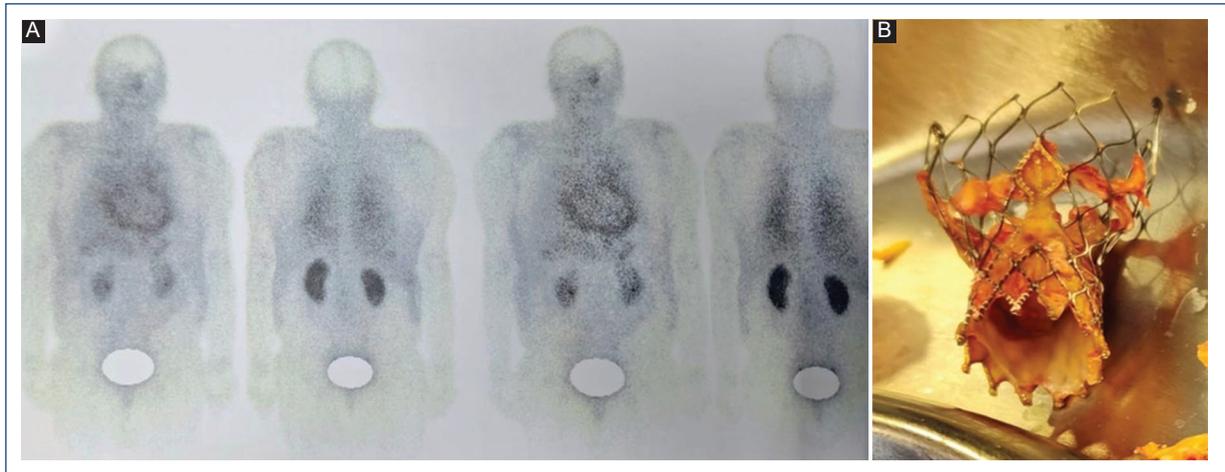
A: technetium-99m-ubiquicidin 29-41 SPECT-CT scan: focal uptake in the prosthetic aortic valve area and pericardium. B: transcatheter aortic valve replacement endoprosthesis extracted with fibrin and signs of edema on the prosthetic leaflets and skirt. SPECT-CT: single photon emission computed tomography-computed tomography.
